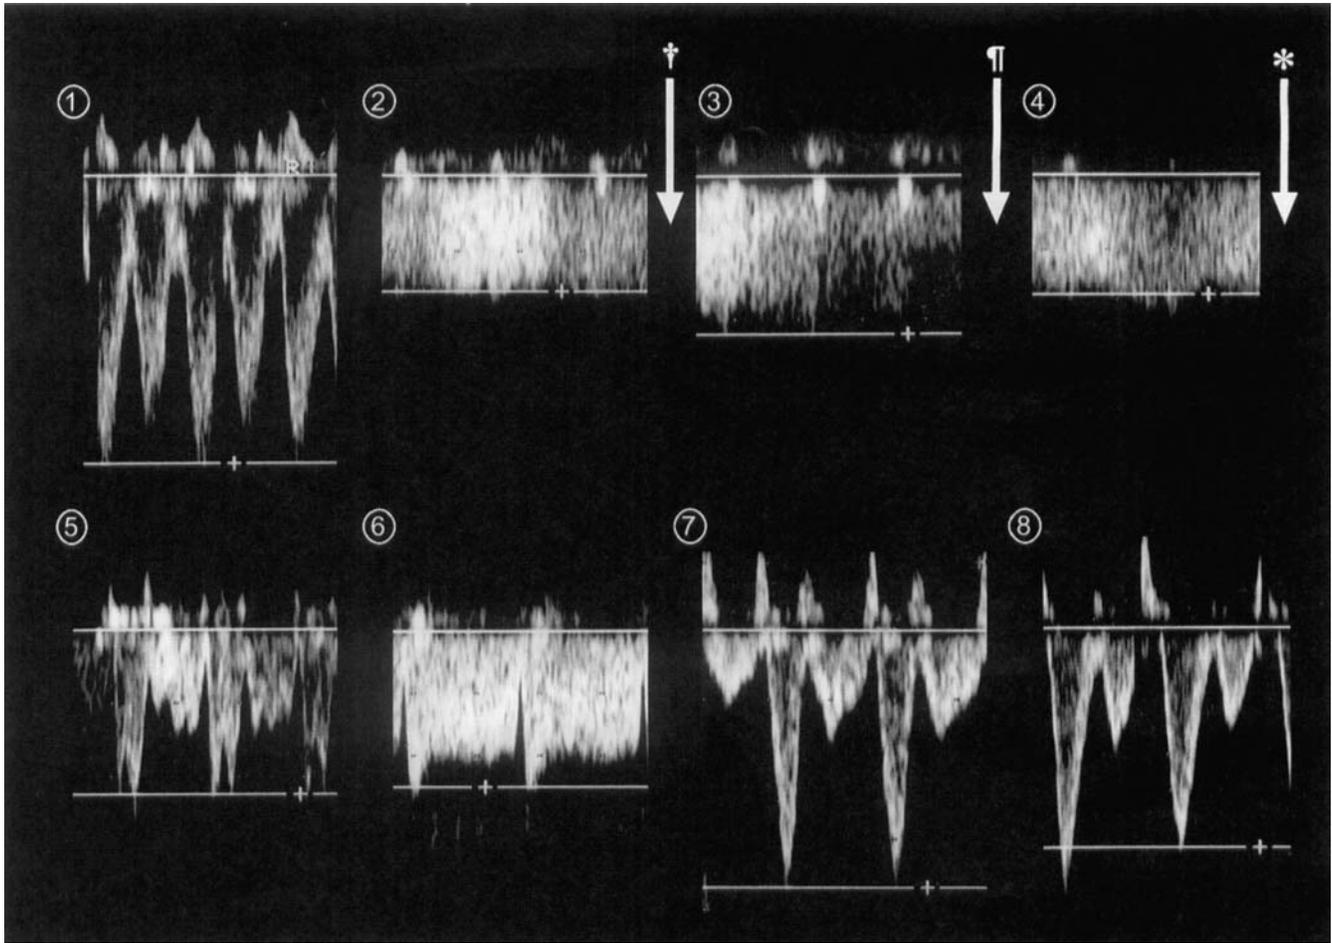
Serial changes in waveform of a graft hepatic vein (middle hepatic vein) with Doppler US.
